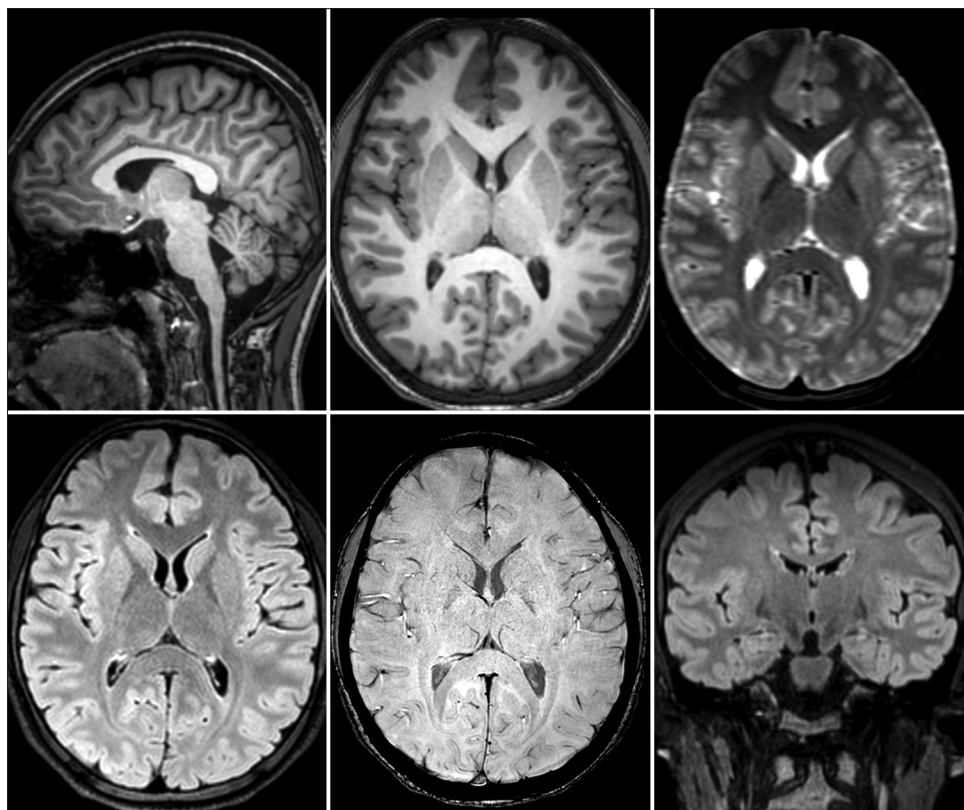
Normal MRI Brain
